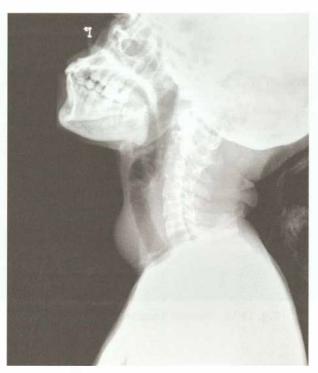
X-ray of the neck—lateral view
